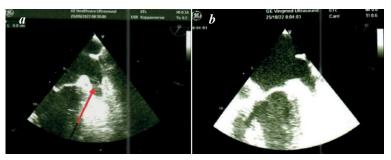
Transoesophageal echocardiography (TEE) of patient Ts.: a soft mural thrombus in the LAA (indicated by arrow) during dabigatran therapy; b - no evidence of LAA thrombosis during warfarin therapy.
